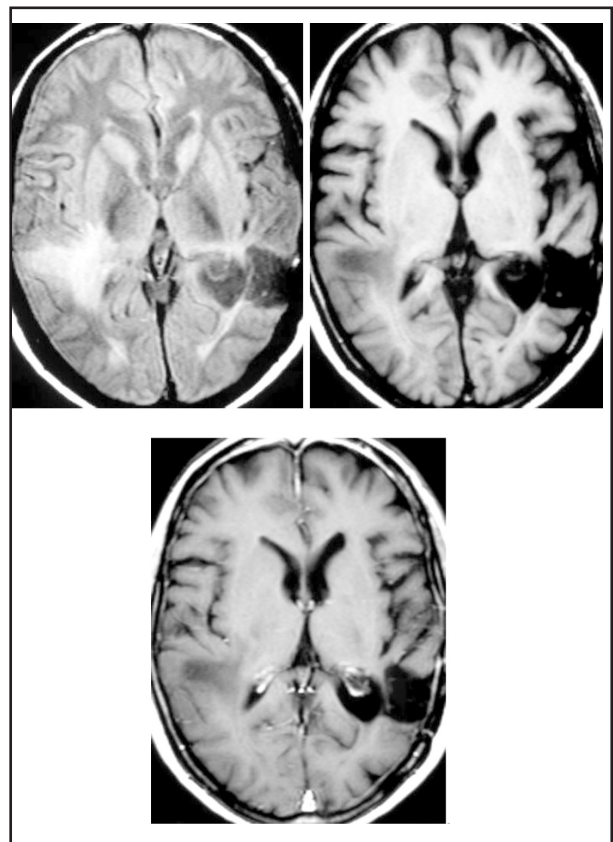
Axial MRI images showed restriction of pathological enhancement of lesion after dispensation of steroids.
